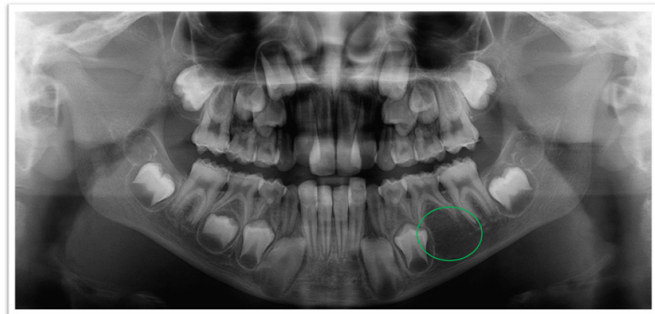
Orthopantomograph of the VDDR-I patient showing missing left mandibular second premolar.
